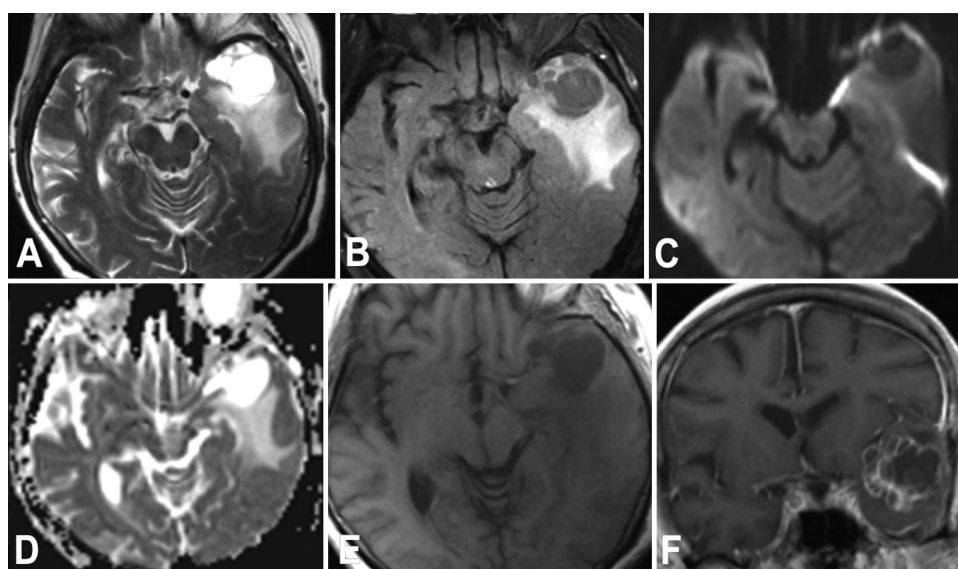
Preoperative MR images obtained in the patient: axial T2-weighted image (A), axial FLAIR image (B), axial diffusion-weighted image (C), axial apparent diffusion coefficient map (D), axial T1-weighted image (E), and coronal T1-weighted spin-echo image after intravenous contrast administration (F).
